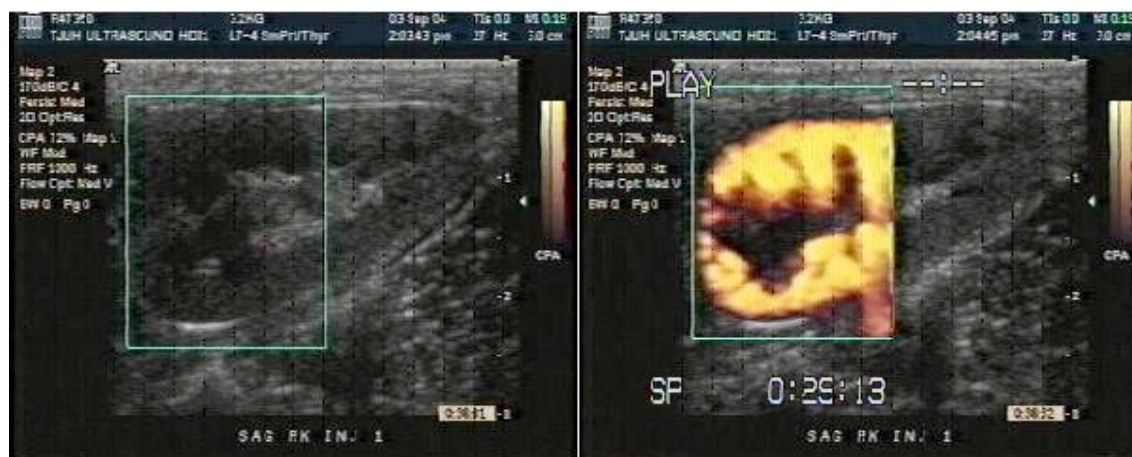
Color Doppler image of a rabbit kidney before (left) and after injection of SB-loaded PLA. Four percent of SB were loaded using incorporation. CA was injected through the ear vein. Power Doppler imaging was done with a broad bandwidth L12-5 transducer (5-12 MHz), a PRF of 700 kHz and a mechanical index of 0.33.
